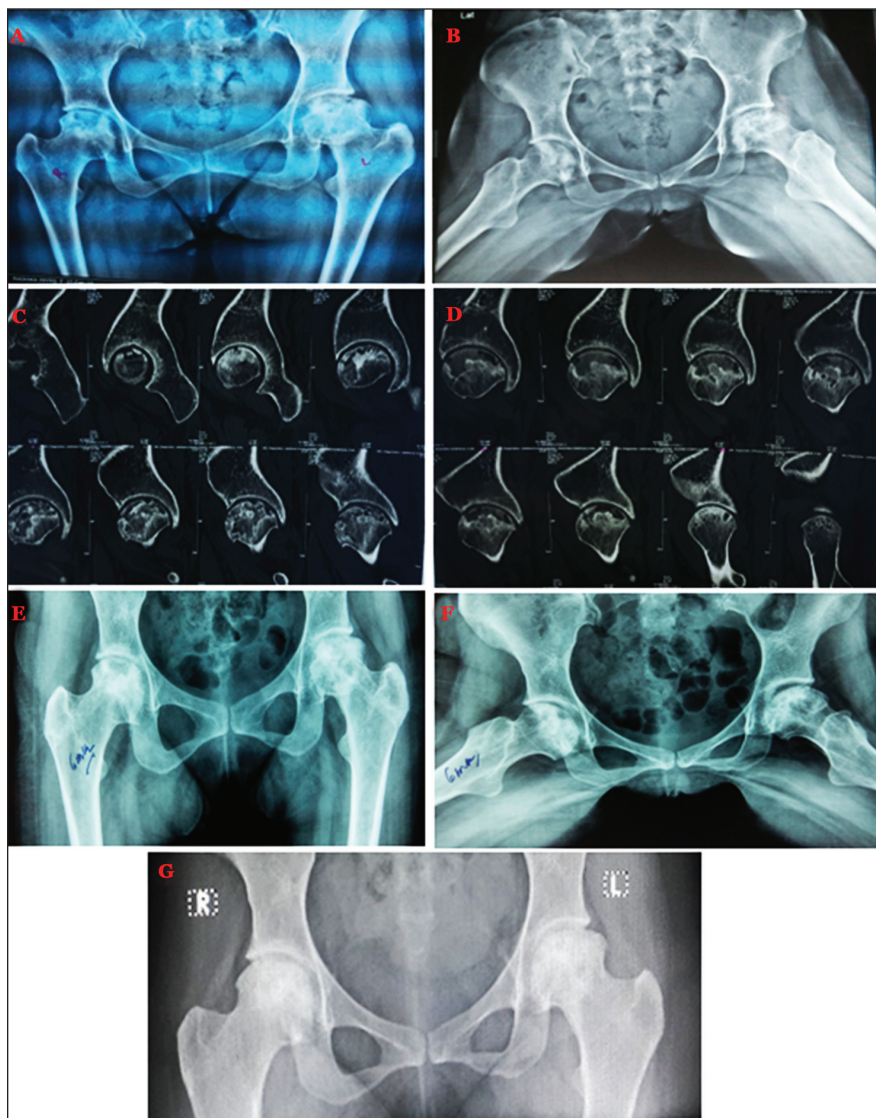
Patient F1. Preoperative anteroposterior radiographs (A, B). Preoperative computed tomography scans. There is extensive bilateral femoral head involvement (>30%), with 2 to 4 mm of depression of the crescent (C, D). Anteroposterior radiographs 6 months after treatment (E, F). Anteroposterior radiograph 6 years after treatment. Both femoral heads show arrest of osteonecrosis progression in a patient at high risk for collapse (G).
